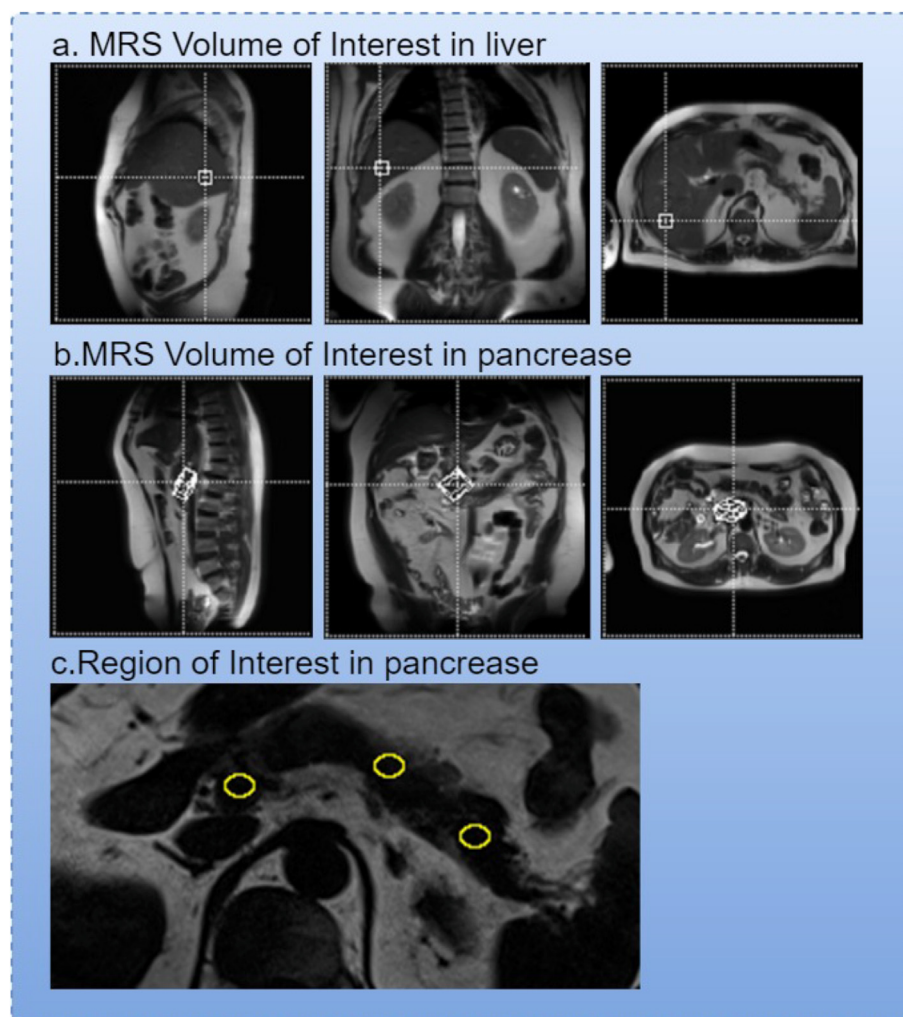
Assessment of hepatic and pancreatic fat content in MRI. a.) The volume of interest located in liver, b.) The volume of interest located in pancreas, c.) The region of interest (yellow circle) on MRI fat image.
